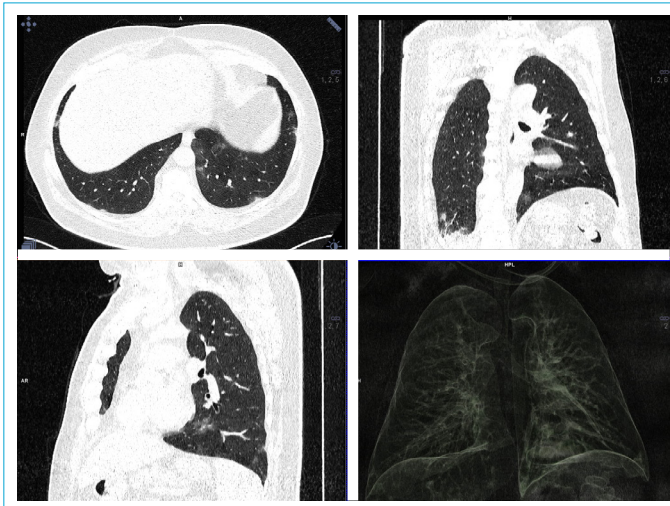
Ground-glass density infiltrates in bilateral lung lower lobe basals in low-dose non-contrast thoracic CT scan.
